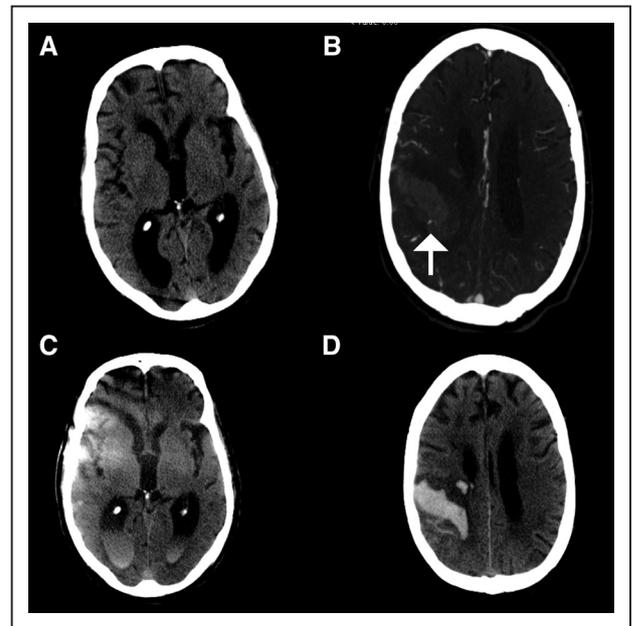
Baseline computed tomography (A) and computed tomographic angiography (B) reveal a parenchymal hematoma with spot sign (arrow). Follow-up imaging at 24 hours reveals a new intraventricular hemorrhage of 13 mL (C) and a smaller parenchymal hematoma (D). Using conventional parenchymal expansion definitions, this patient would be classified as a non-expander, in spite of a net total intracerebral hemorrhage volume increase of 7 mL.
